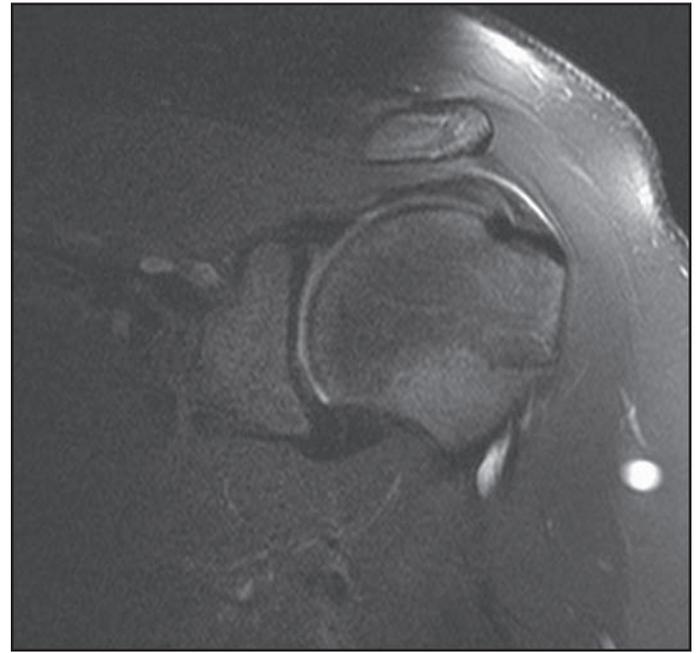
In this coronal-oblique slice MRI of a 14 year-old athlete, note the proximity of the humeral head and acromion with the signal changes in the interposed supraspinatus tendon.
